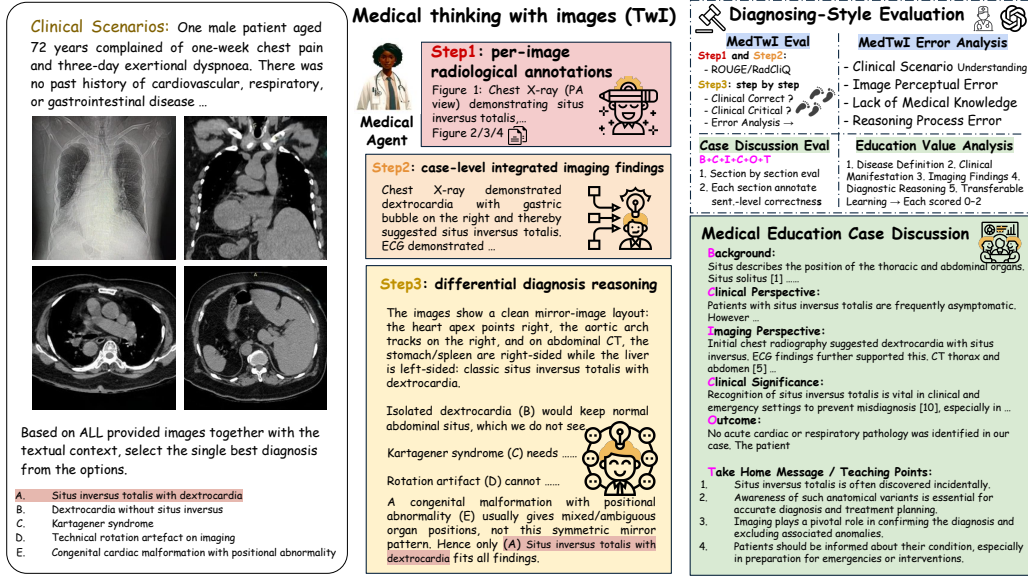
Medical Thinking with Images (TwI): task and diagnosing-style evaluation. Left: a sample case with a clinical scenario, multi-view images (e.g., radiograph + CT), and a five-option single-best-answer diagnosis. Middle: TwI’s three supervised steps: (1) *Per-Image Findings* (detect and name key radiological signs for each image, expert-annotated, brief statements); (2) *Case-level Integrated Imaging Summary* (synthesize cross-view evidence into a single case summary); (3) *Differential-Diagnosis (DDx) reasoning* (align the summary with candidate diagnoses, rule out distractors with image-grounded arguments, and pick the most consistent answer). Right: *Beyond-accuracy evaluation*. Steps 1–2 use automatic metrics (ROUGE / RadCliQ), while Step 3 and the Medical Education Case Discussion are assessed with structured human- and LLM-judge rubrics that check clinical correctness and educational value, localizing failures in image reading, cross-view fusion, and teaching quality (see Section 4).
